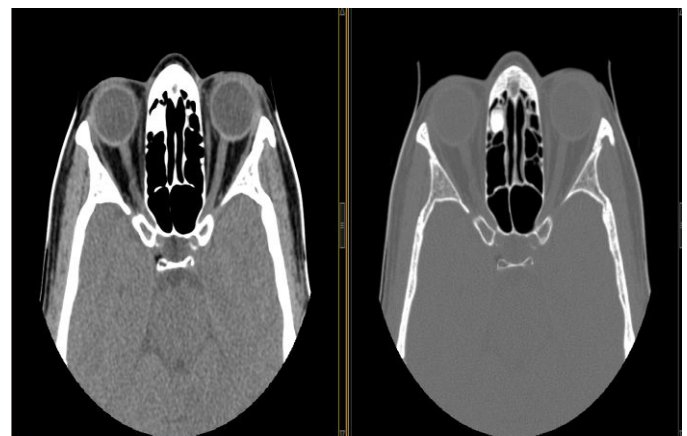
Axial CT at the level of the orbit showing an osteoma of the right ethmoidal sinus
